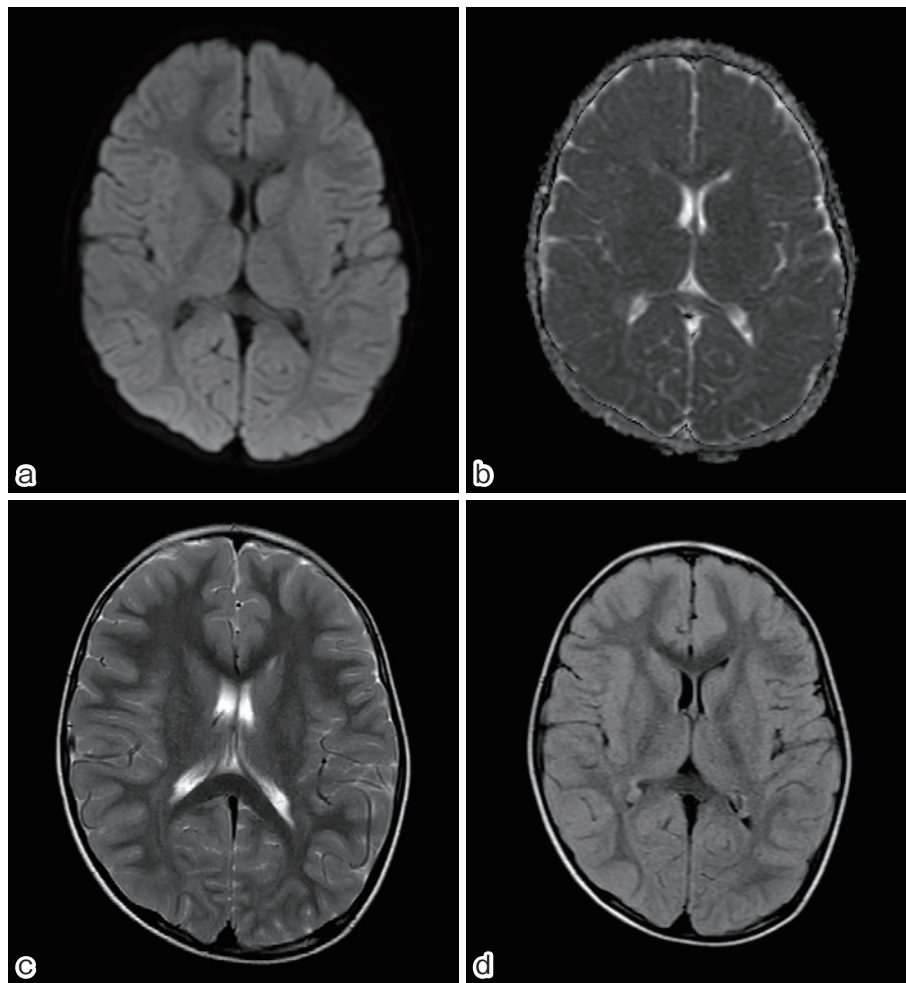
No abnormal findings on brain MRI: a) DWI, b) ADC map, c) T2WI, d) FLAIR.
